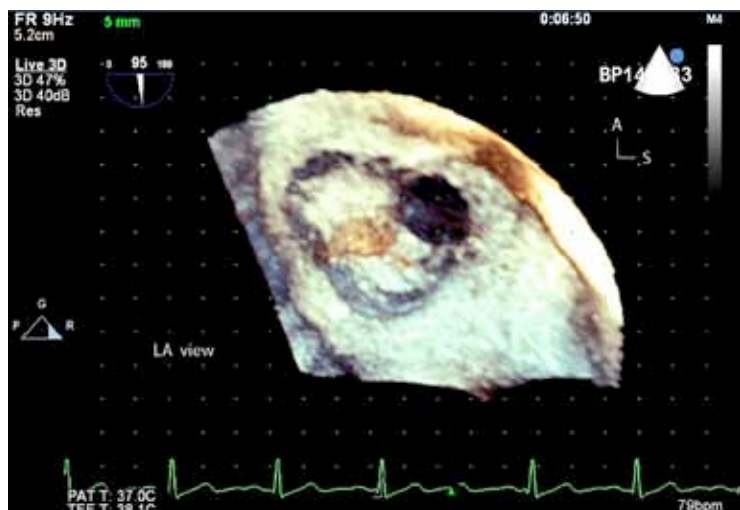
3D Transesophageal (TEE) still frame volume image of a moderate sized ostium secundum atrial septal defect view from the left atrial aspect. The defect is round, symmetrical and located just below the limbus of the fossa ovalis. The remaining portion of the septum primum is intact.
